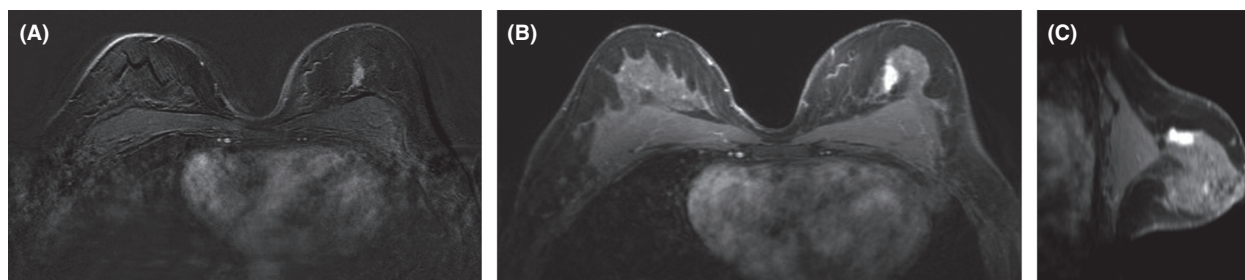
Routine screening breast MRI 2 weeks later: (A) axial T1-weighted subtraction 90 sec post contrast, (B) axial and (C) sagittal 3D T1 fat saturated images 270 sec post contrast. At 11 o'clock in the upper inner quadrant of the left breast there is a segmental area of non-mass enhancement measuring 23 × 23 × 11 mm. Even in retrospect, this was mammographically occult.
